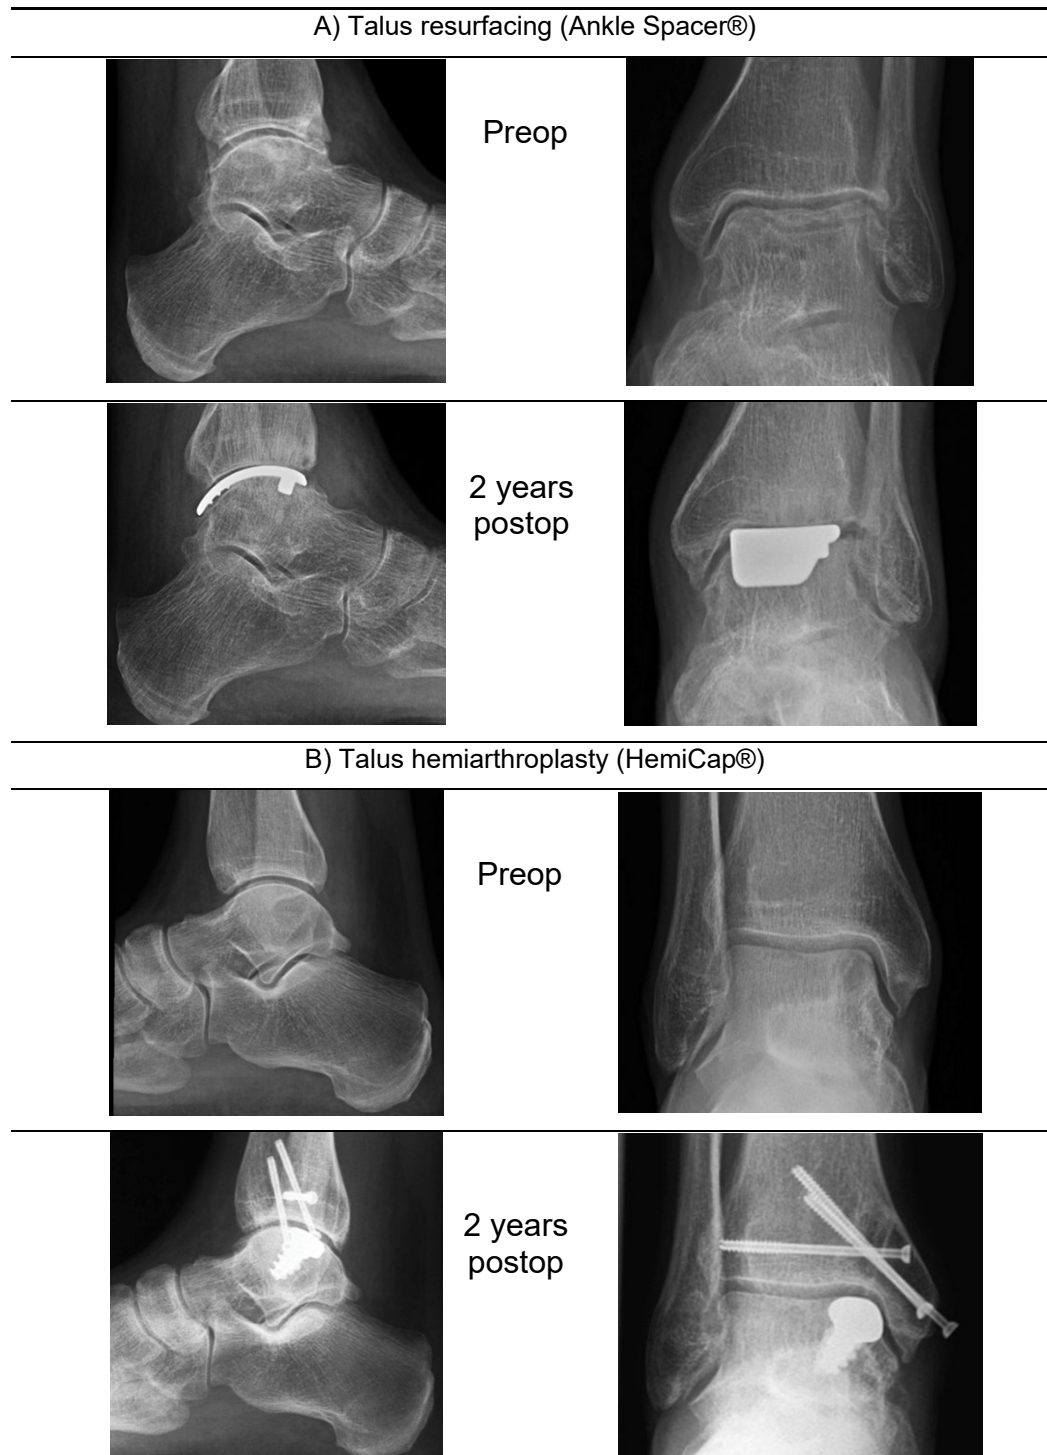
Representative preoperative and 2-year weight-bearing radiographs of A) talus resurfacing (41-year-old male subject with hemophilic arthropathy), and B) talus hemiarthroplasty (55-year-old male subject with a chronic medial post-traumatic OLT).
